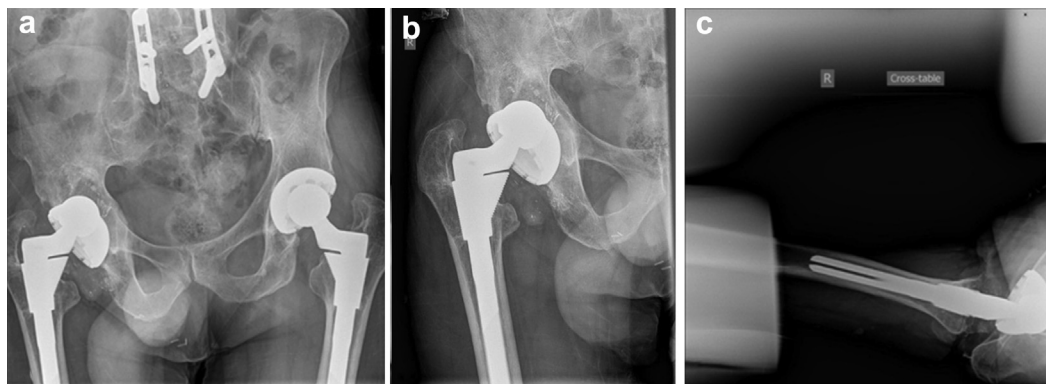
AP pelvis (a) and lateral right hip (b) radiographs taken during initial emergency room visit. Radiologist read as anterior dislocation of femoral head component from the acetabular component. The radiologist also noted ill-defined lucency (c) about the femoral and acetabular components possibly reflecting underlying particle disease.
